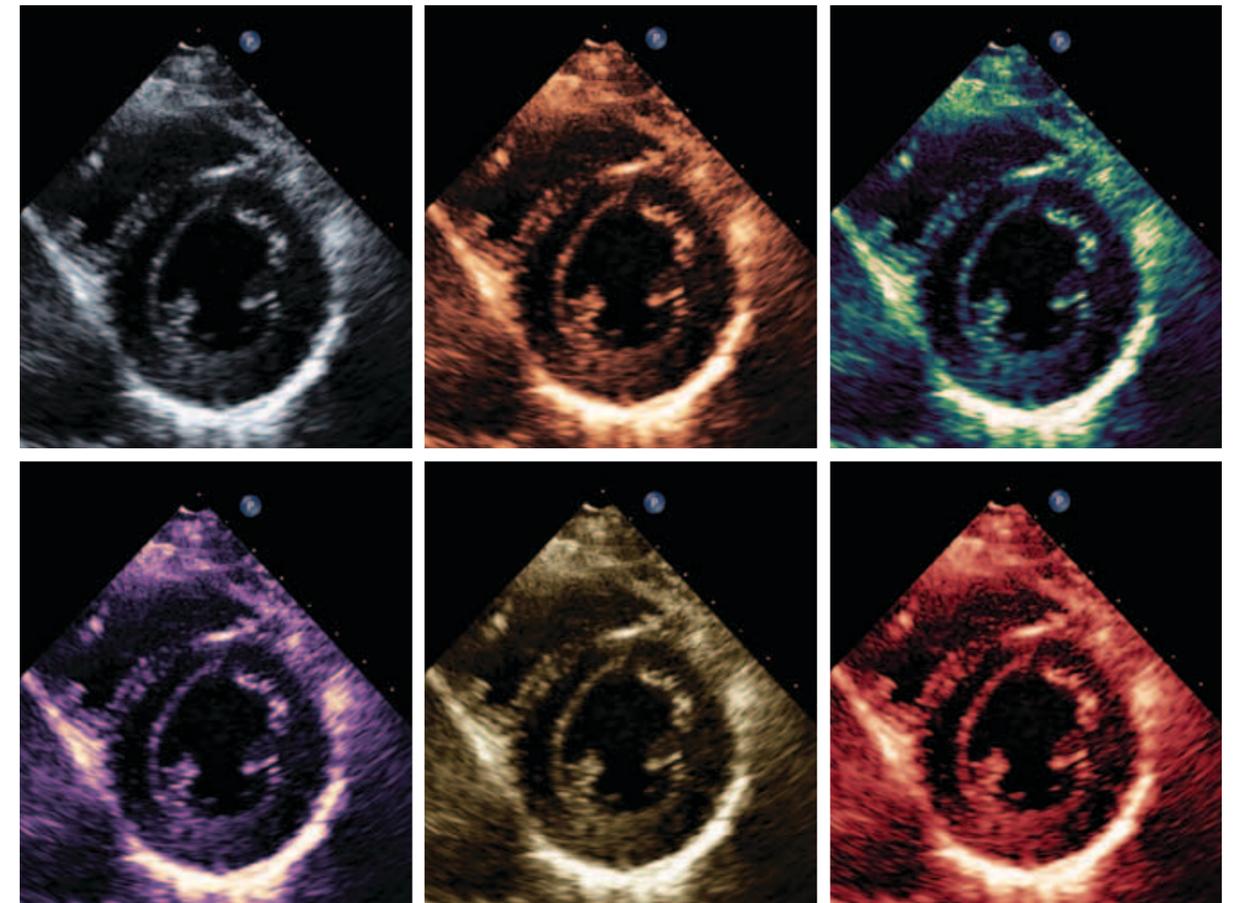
This series of images acquired from the parasternal short axis view at the level of the papillary muscles displays a greyscale map (top left) and various B-colour maps.
